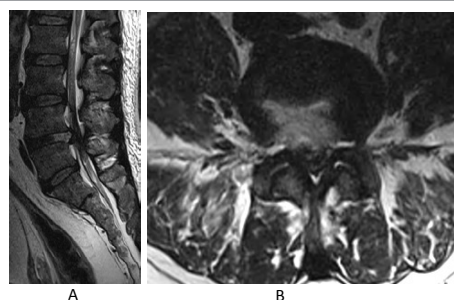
Second surgery post-operative MRI repeated after the final procedure showing well decompressed spinal canal.
